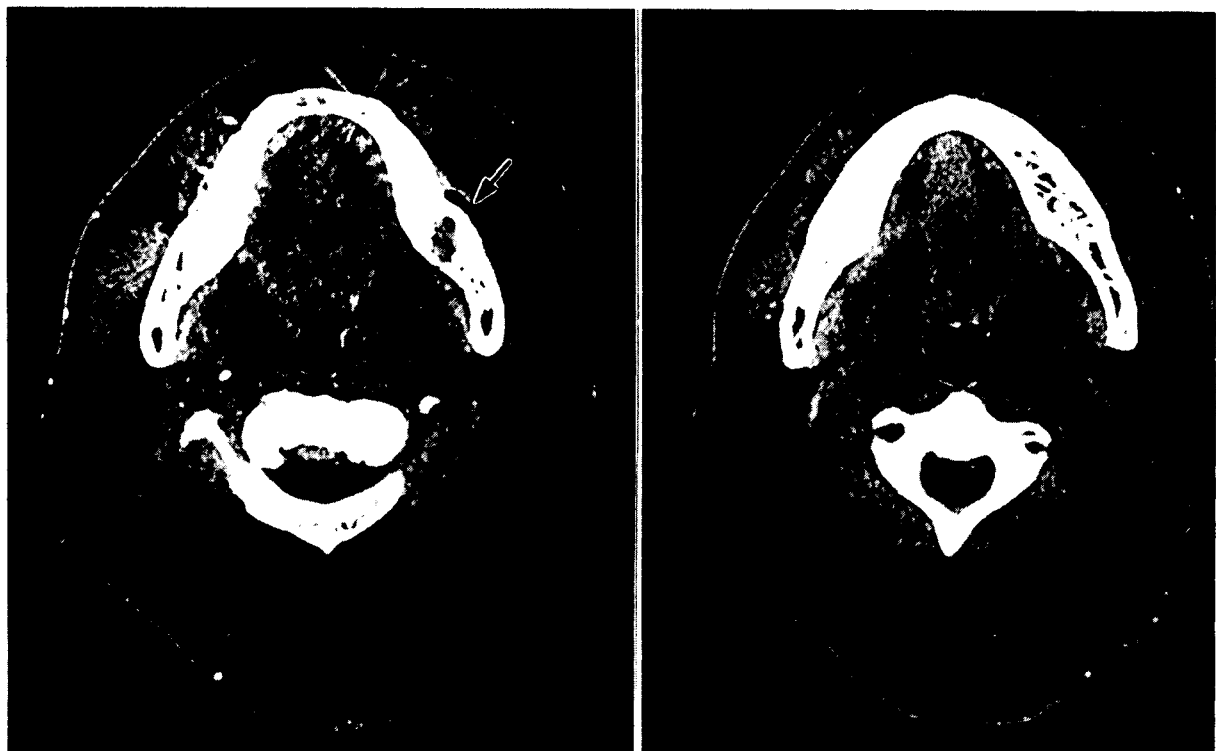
Three days later: CT showing emphysema at the lateral aspect of mandibular body, but no emphysema nearby the lower border of mandible.
